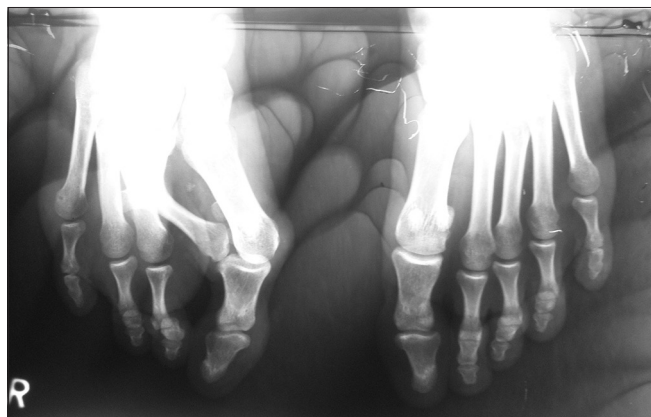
Radiograph of lower extremity showing deformity of the second metatarsal and the absence of phalanges of the second digit
